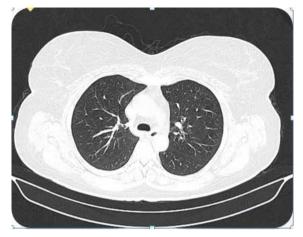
Normal thoracic CT scan
